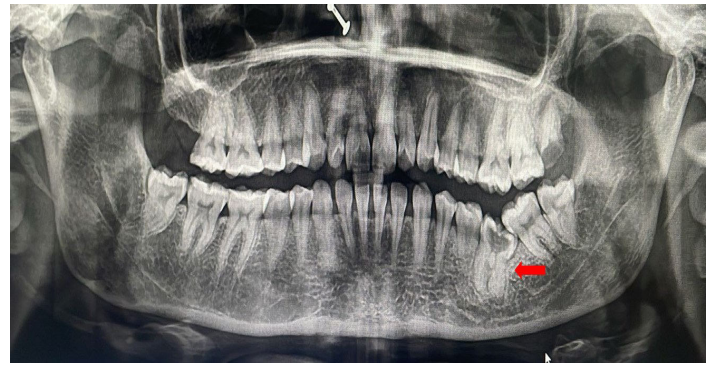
Panoramic radiograph showing a distoangular impacted mandibular left first molar with extensive carious destruction.
